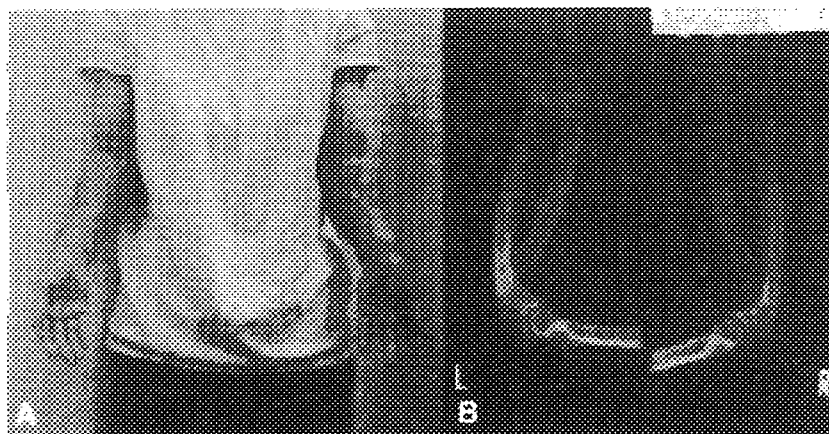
Forearm of the proposita. A: Note Madelung deformity with bilateral cubitus valgus. B: Roentgenograms. Note curvature of radius and ulnar bones.
